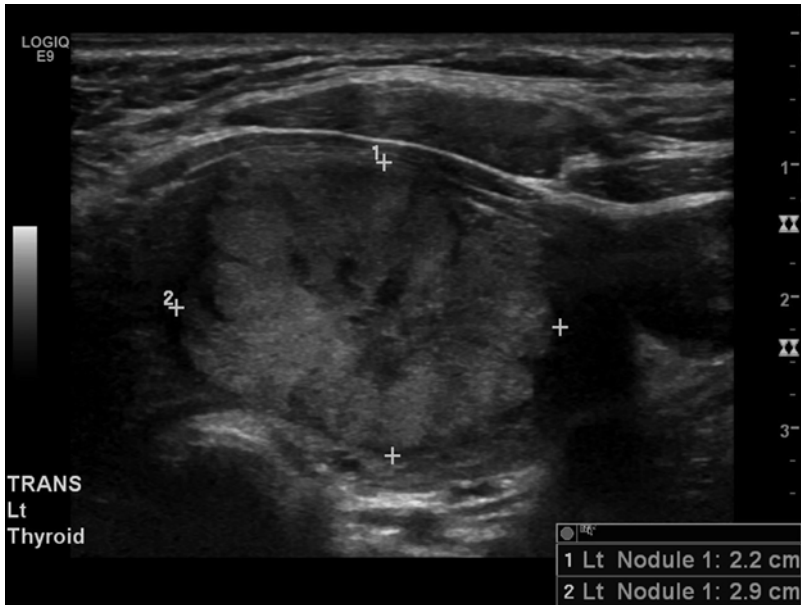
Thyroid ultrasound of patient in Fig. 4.3 demonstrates a 2.2×2.9×3.7 cm lobulated solid mass in the left lobe of the thyroid corresponding to the hypofunctioning area seen on scintigraphy
